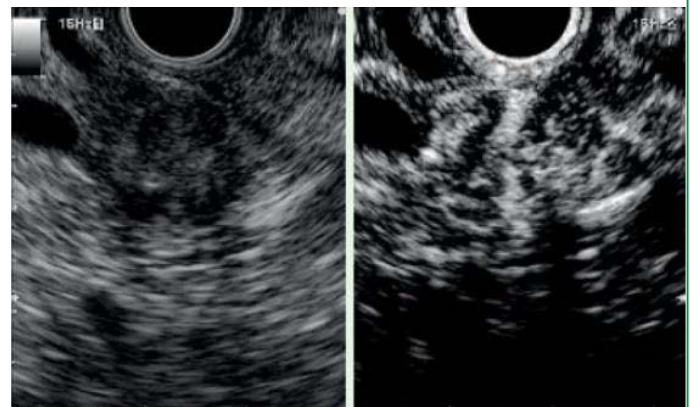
Conventional B-mode (left side) and contrast-specific (ExPHD)-mode (right side). Incidentally discovered hypoechoic 10-mm lesion in the body of the pancreas, showing a hypersignal with homogeneous enhancement after intravenous administration of SonoVue. Final diagnosis, well-differentiated neuroendocrine tumor, was obtained by endoscopic ultrasound-guided fine-needle aspiration.
